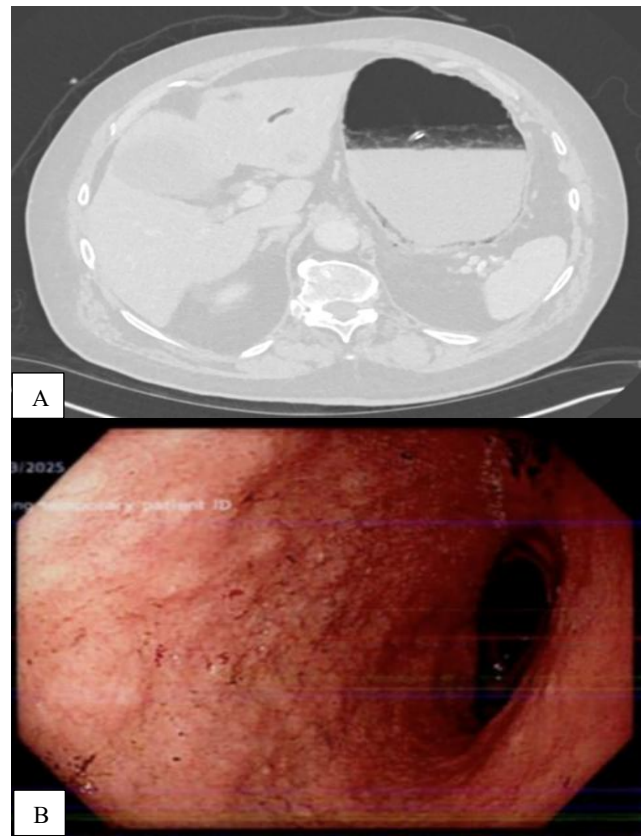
(A) Axial slice image (left) of the abdominal CT with portal venous contrast showing PVG in segment IV of the liver and pneumatosis in the posterior gastric wall. (B) Endoscopic image (right) near the GOJ showing inflammatory changes.
